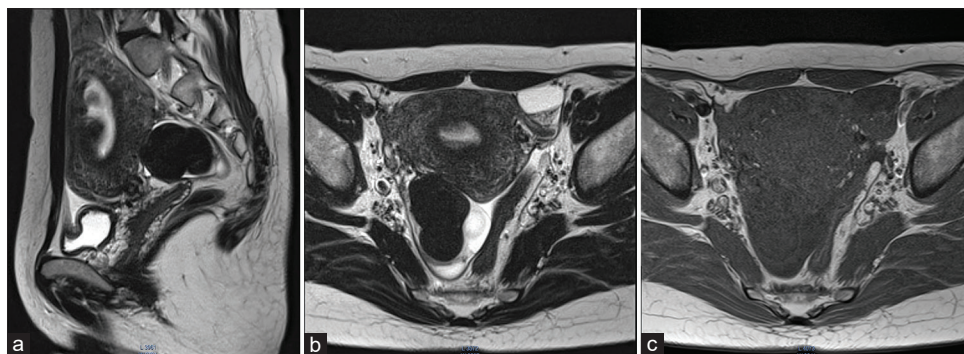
(a-c) Pelvic magnetic resonance imaging. (a) Sagittal T2-weighted imaging. (b) Axial T2-weighted imaging. (c) Axial T1-weighted imaging. Magnetic resonance imaging showing a slightly enlarged uterus due to a mass that projected into the uterine cavity. The mass is of low intensity (a-c). The mass in the right ovary is of low intensity (b and c) and 5.5 cm in diameter
